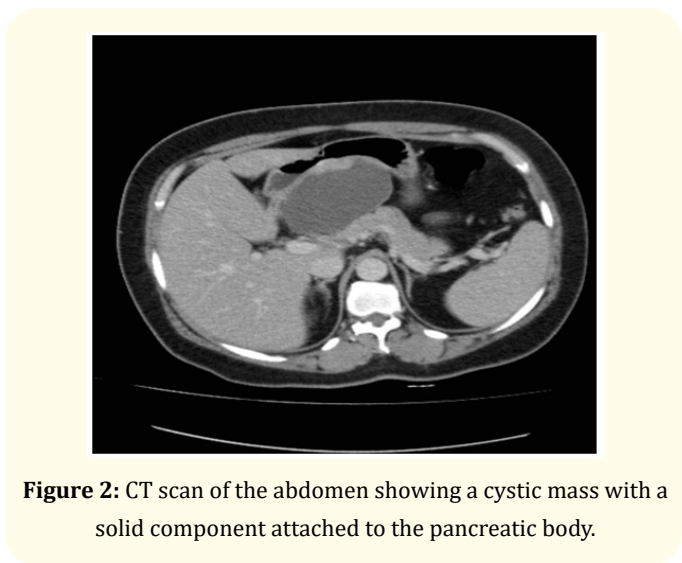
CT scan of the abdomen showing a cystic mass with a solid component attached to the pancreatic body.
